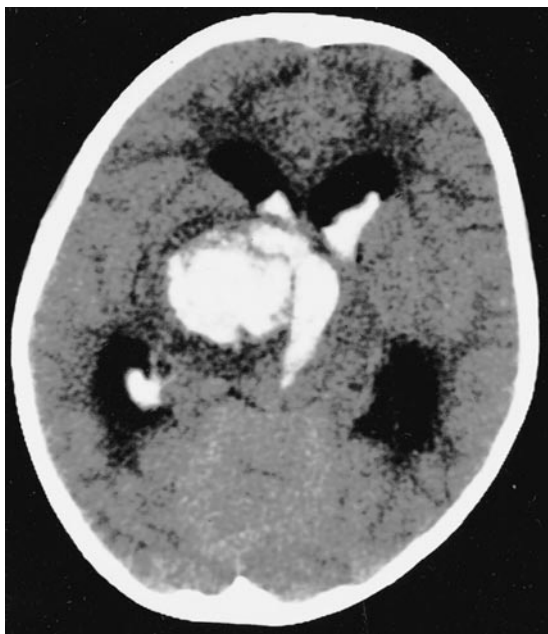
CT scan of the brain shows intracerebral hemorrhage over right thalamic area with ventricular extension and hydrocephalus.
